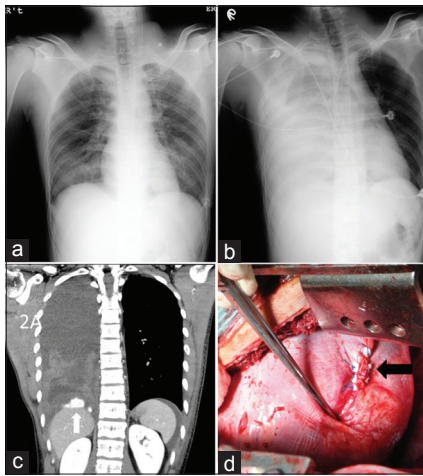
(a) Initial chest X-ray in the emergency room and (b) followed up chest X-ray taken 12 h later. (c) Contrast-enhanced computed tomography scan of chest showed right-sided massive hemothorax with contrast extravasation (white arrow) at the dome of right hemidiaphragm. (d) Operative photograph showed one laceration wound over right-sided hemidiaphragm which was repaired with interrupted horizontal mattress sutures (black arrow)
